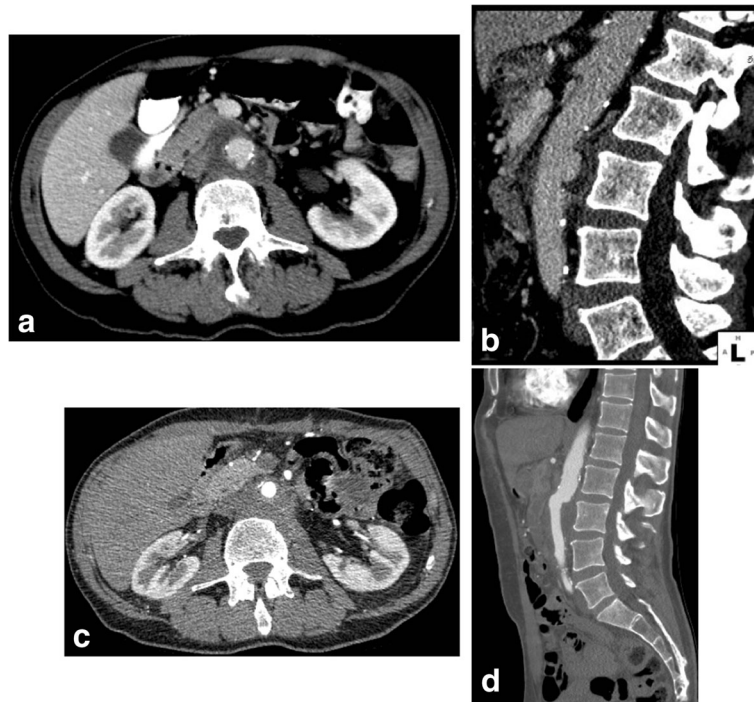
Seventy three year old male with mycotic aneurysm of the abdominal aorta. a Axial and b sagittal images of a portal venous phase exam showing peripherally enhancing hypoattenuating periaortic mass with a focal out-pouching arising from the posterior wall of the aorta consistent with a pseudoaneurysm. Post-surgical repair c axial and d sagittal images of CTA show unremarkable superficial femoral vein graft with no residual pseudoaneurysm
